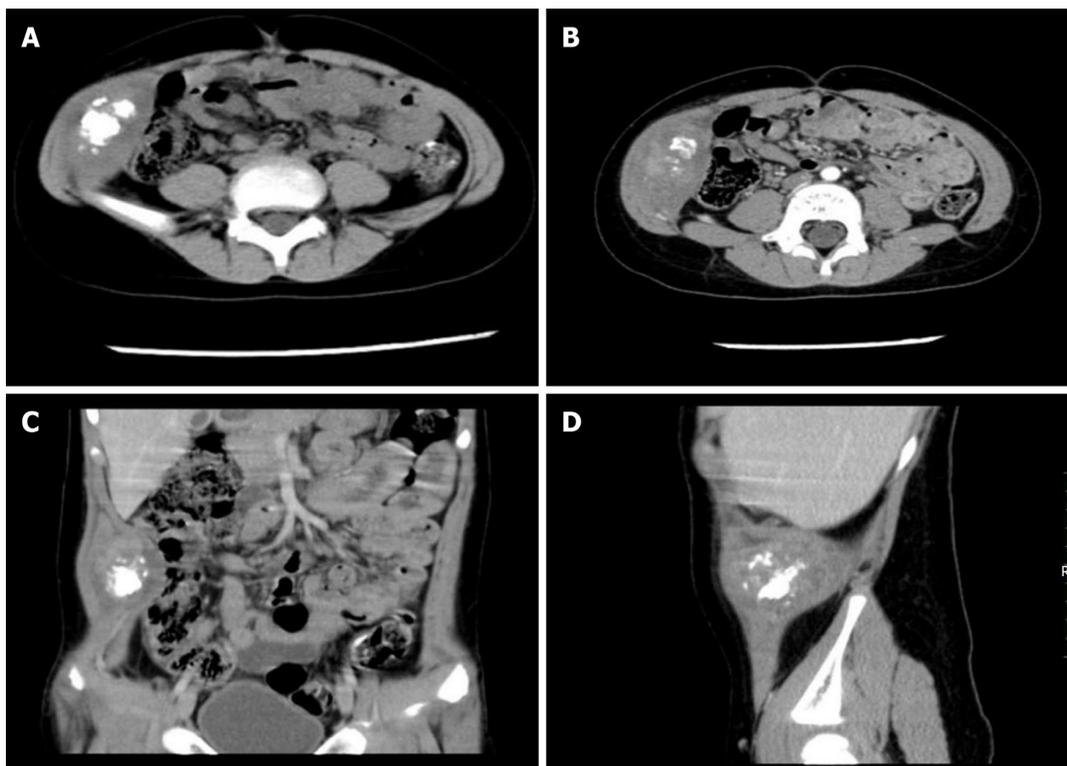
Computed tomography evaluation of Case 1. A: Axial computed tomography image showing a fusiform soft tissue density between the abdominalis obliquus internus muscle and the abdominal transverse muscle in the right inferior abdomen; the middle of the mass has irregular patchy calcification; B: Enhanced image showing uniform enhancement of the mass; C and D: The mass involving the musculus transversus abdominis.
